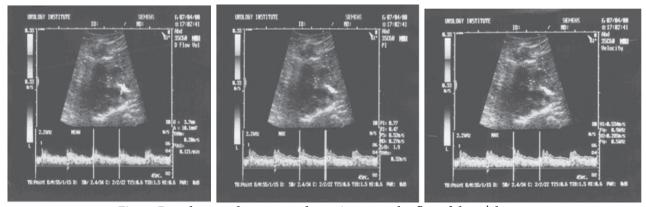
Dopplerography curve under vesicoureteral reflux of the 3rd degree.
